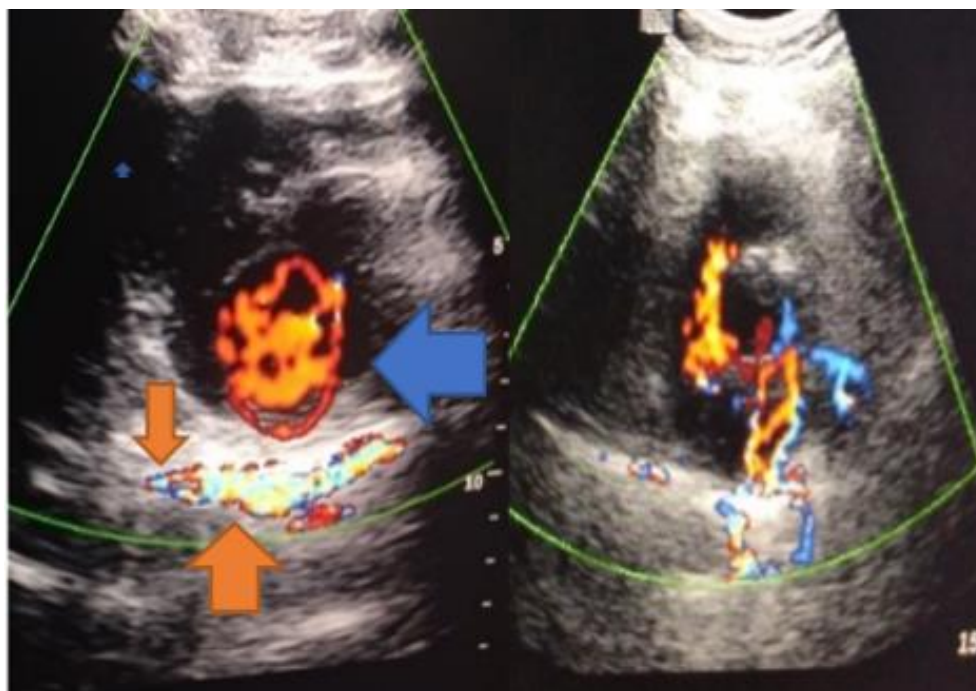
Short - axis parasternal views; on right side; show CAs of middle LV level that connected to each other via parts of the network arteries (blue arrow), and the posterior descending part (because the level at papillary muscles, not at atrial level that shows circumflex artery), with another artery from right to left (red arrows), on the left side the horizontal view of proximal CAs at level of aortic annulus were seeing.
